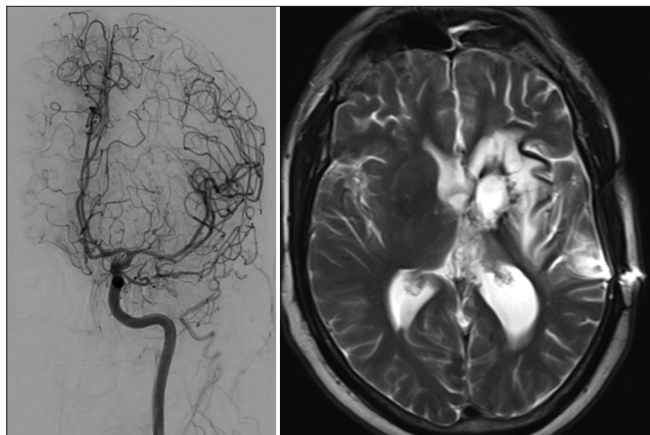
Left digital subtraction angiography image (left internal carotid artery catheterization) – Complete obliteration of the arteriovenous malformation with minimal angiod tissue without early venous drainage. Right - T2-weighted axial image: No obvious mass component at the site of surgery due to residual or recurrence of the known cysts.
